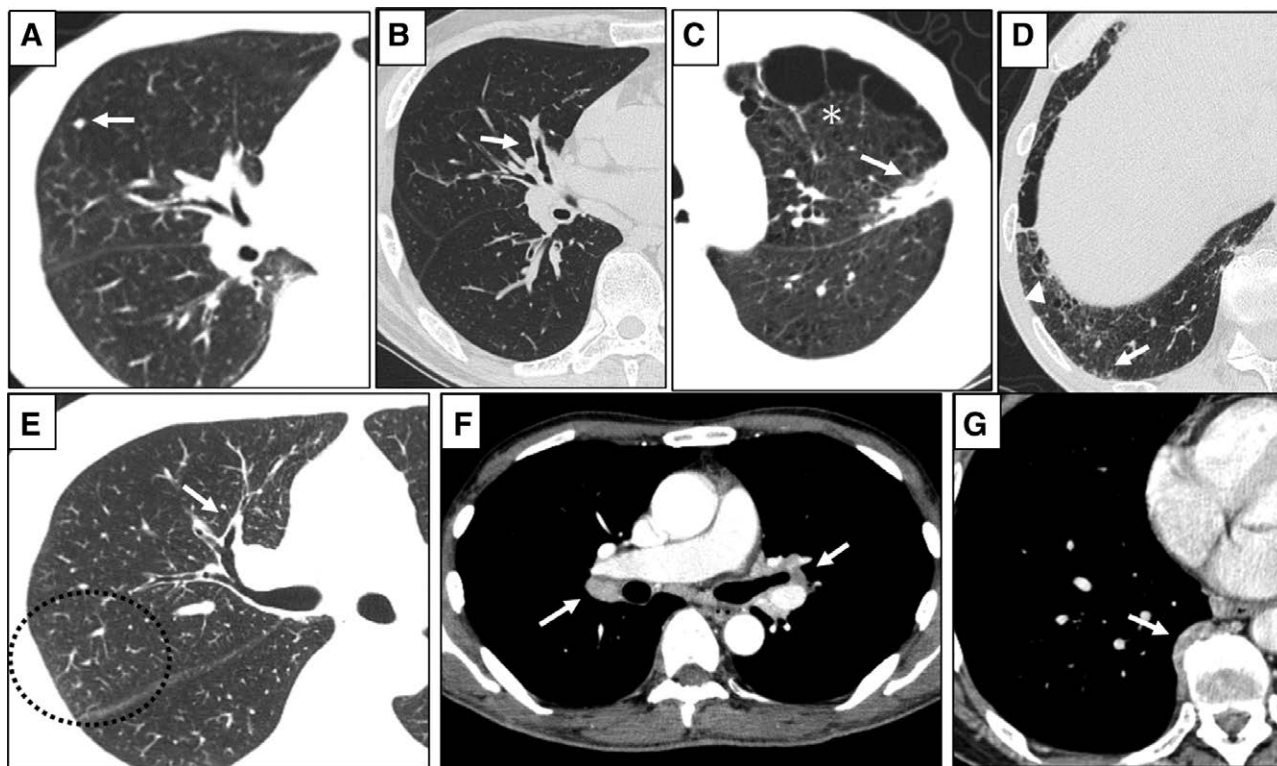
Typical chest high-resolution computed tomography images of a patient with autoimmune pancreatitis. (A) Solid nodule (arrow), (B) bronchovascular bundle thickening (arrow), (C) consolidation (arrow), emphysema (*), (D) reticular opacities (arrow), traction bronchiectasis (arrowhead), (E) centrilobular nodules (circle), and thickening of the bronchial wall (arrow), (F) hilar lymph node swelling, and (G) paravertebral band-like lesion.
